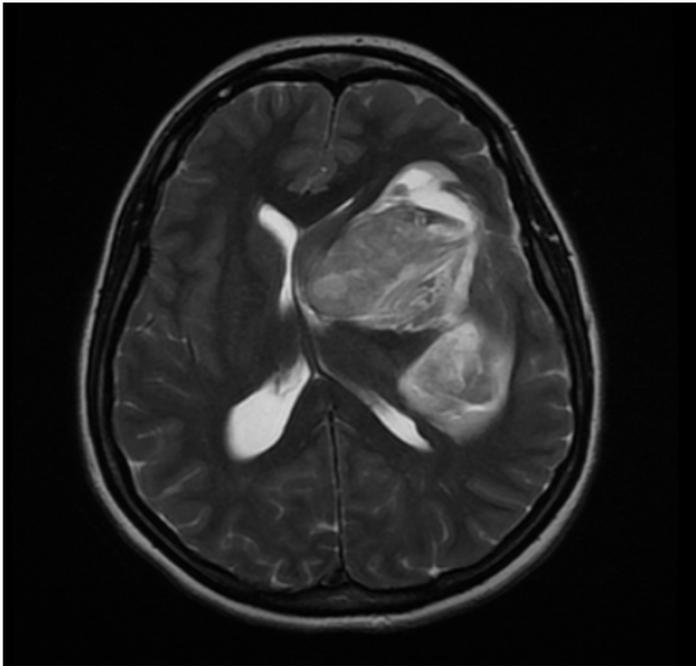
MRI that show a big left hematoma that compromise middle line.
